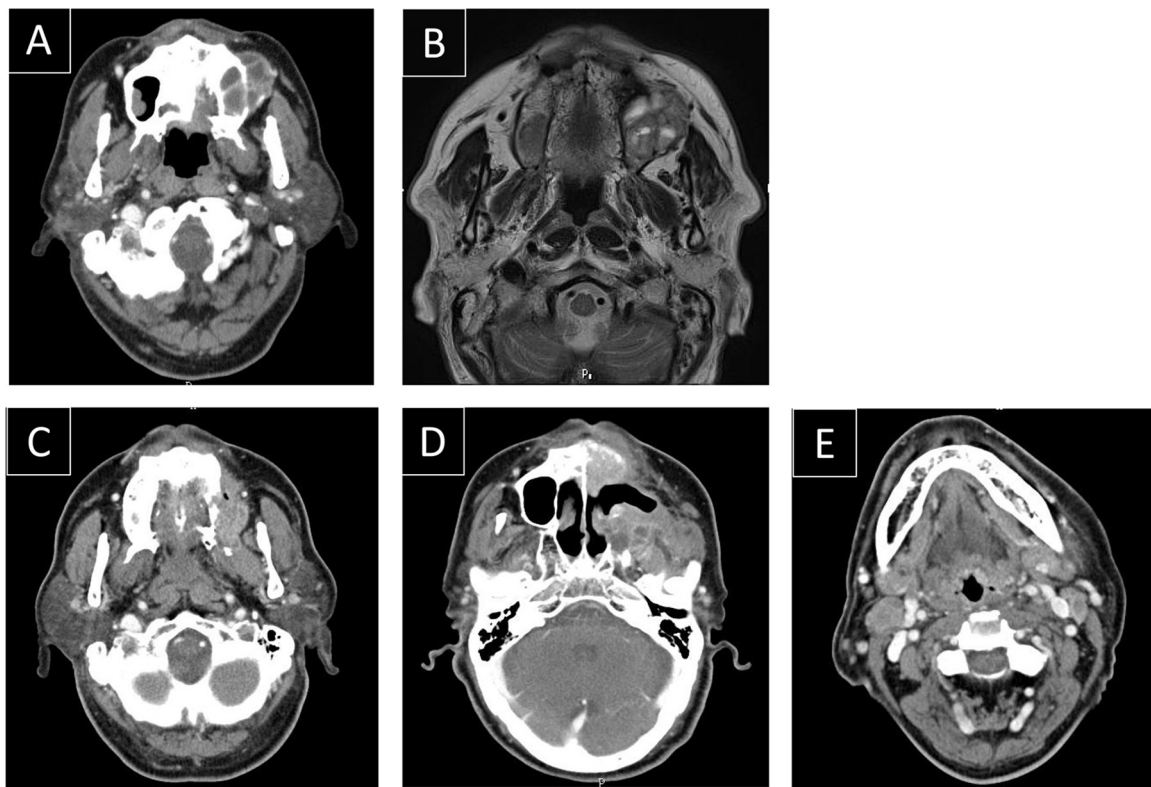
A) At initial diagnosis, CT shows a well-defined mass in the left maxilla with resorption of the maxillary bone and sinus. B) T2-weighted MRI shows the cystic and solid portions of the lesion. C) At the time of recurrence, CT shows an ill-defined mass demonstrating variable densities and bony erosion of the maxilla. D) At the second recurrence, CT shows two poorly demarcated masses extending into the left maxillectomy cavity. E) Bilateral cervical regions show a large number of lymph node metastases.
